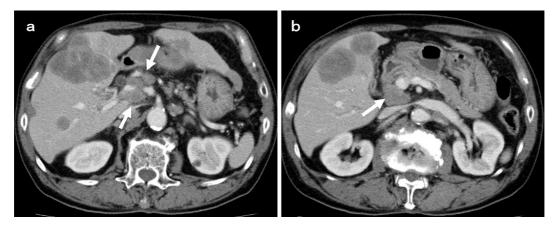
Contrast-enhanced computed tomography showing multiple metastatic liver tumors and metastatic lymph node swelling. a: Lymph node swelling around the extrahepatic bile duct (arrows). b: Lymph node swelling near the pancreatic head (arrow).
